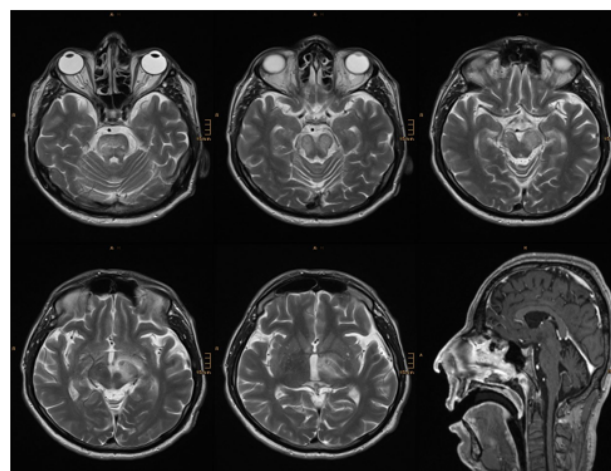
MRI-series of five T2 axial and one T1 sagittal with gadolinium: After 5 days of methylprednisolone therapy, decline of the pathological findings with recurrent edema/space-occupying effect and a decline in gadolinium enhancement with further extensive high T2 signal changes focusing mesodiencephalic (bilaterally in the pons, the right cerebellar peduncle and cerebral peduncle, thalamus and left sided posterior capsule).
